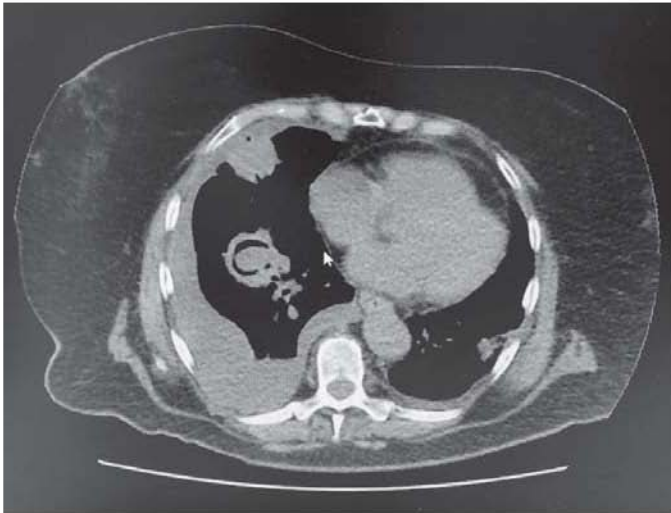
Thoracic CT-scan image of a patient with aspergilloma (air-crescent sign)
